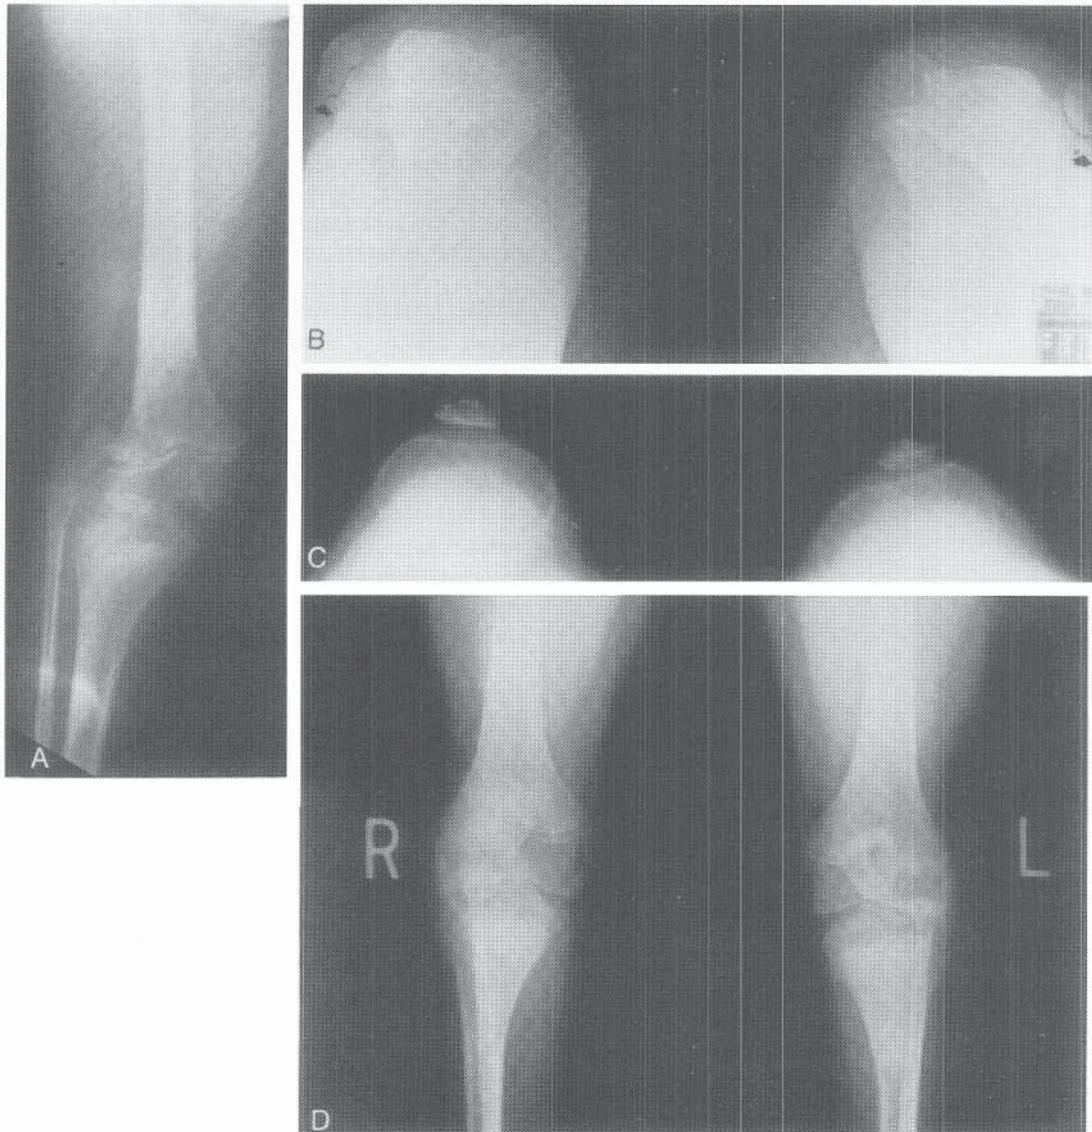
Bilateral congenital dislocation of the patellae in an 8-year-old girl. A and B, Preoperative radiographs showing complete lateral dislocation (*arrows*). C and D, Postoperative radiographs showing reduction.
